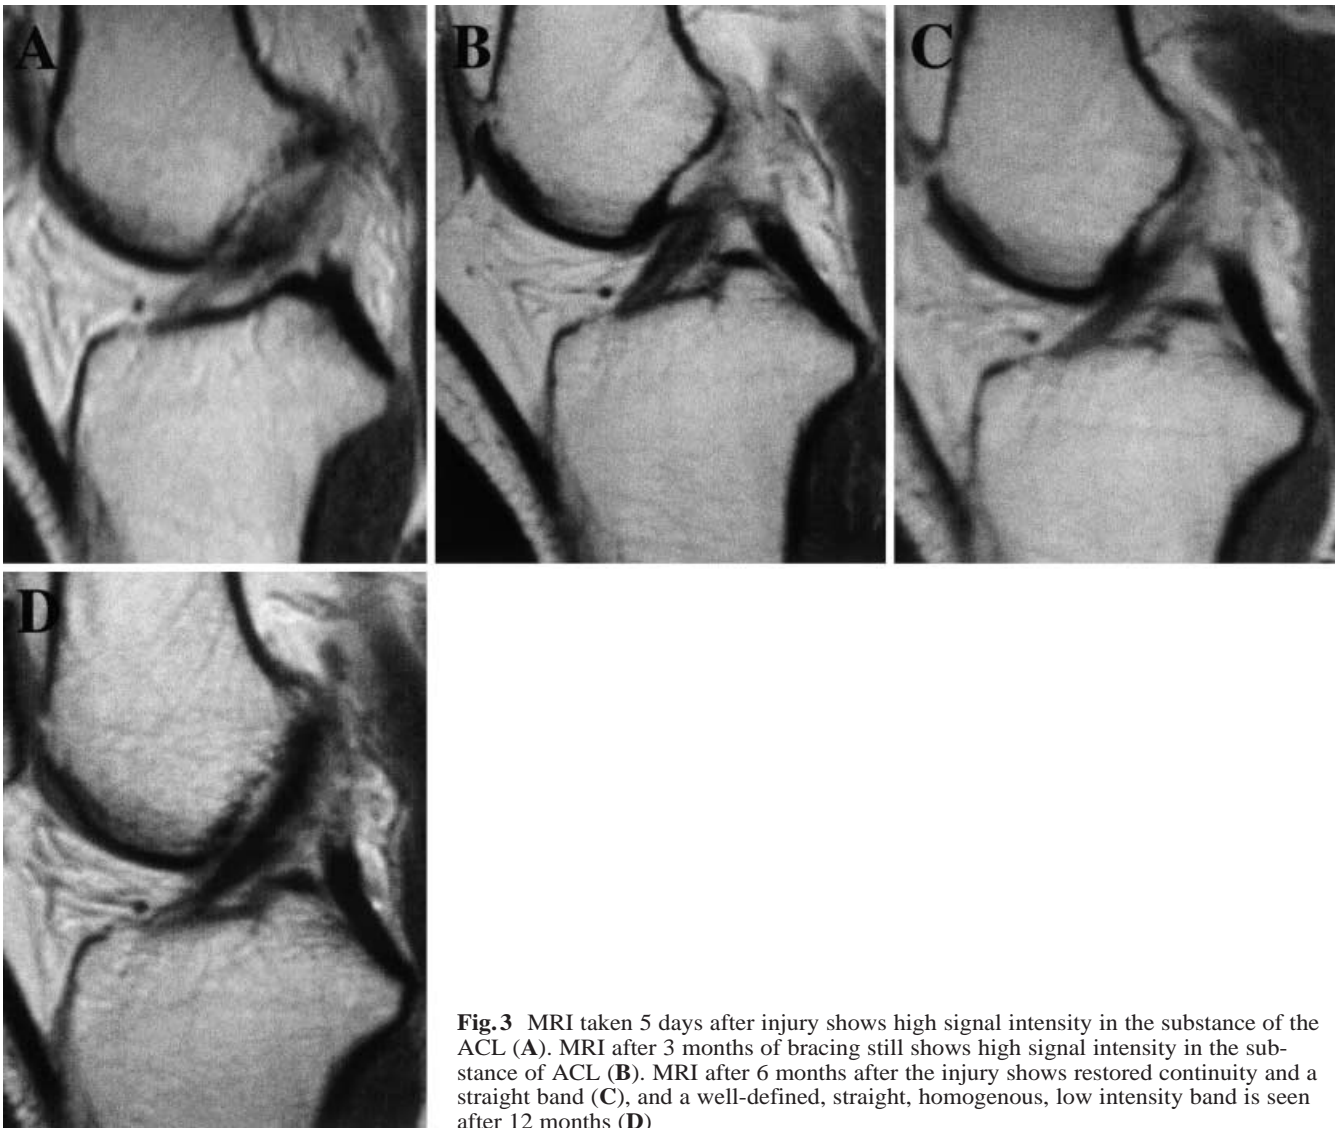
MRI taken 5 days after injury shows high signal intensity in the substance of the ACL (A). MRI after 3 months of bracing still shows high signal intensity in the substance of ACL (B). MRI after 6 months after the injury shows restored continuity and a straight band (C), and a well-defined, straight, homogenous, low intensity band is seen after 12 months (D)
